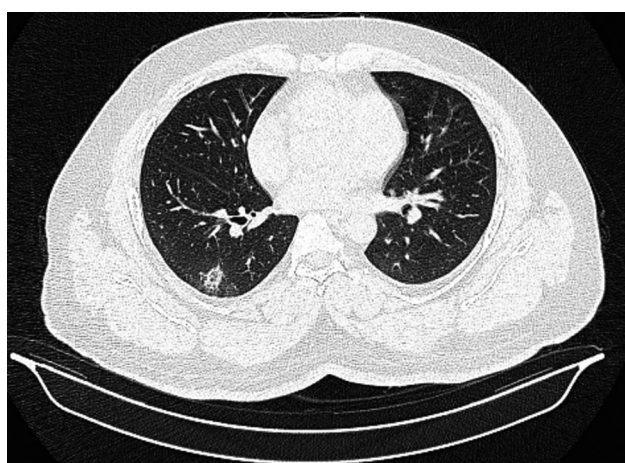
Figure/table-10: Axial HRCT chest image shows consolidatory changes with airbronchogram.
